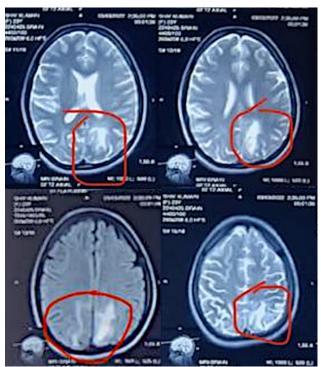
showing posterior parieto-occipital hyper densities in the cortex and subcortical white matter on T2 Weighted FLAIR MRI sequence
